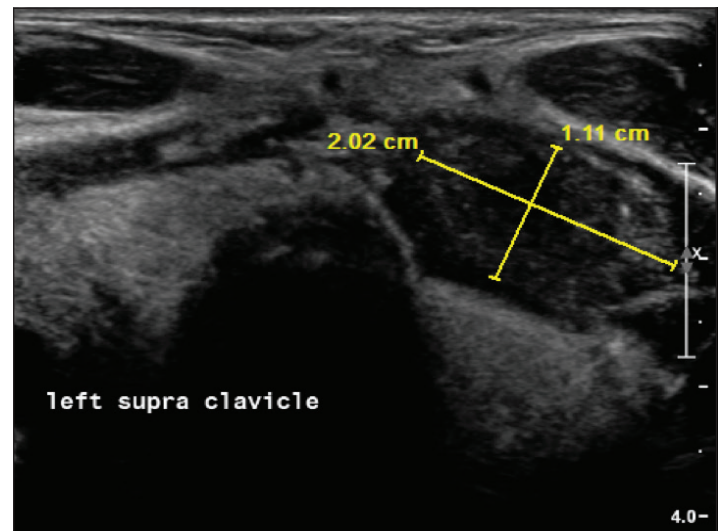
Ultrasound of the anterior chest wall showing a 2.02 cm x 1.11 cm enlarged, heterogeneous, hypervascular area cephalad to the left sternoclavicular joint, no definite fluid collection.
